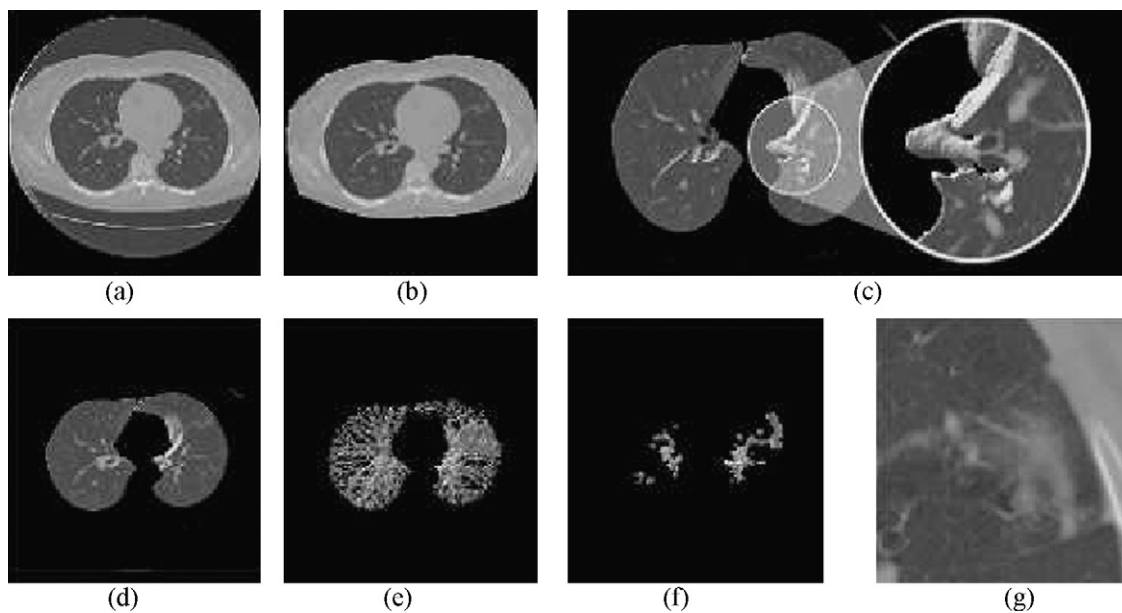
Case study – unsuccessful detection. (a) 2D visualization of the original CT exam. (b) Eliminates of all artifacts external to the patient's body. (c) Removal of thorax just remaining the parenchyma and shows the incorrectly eliminated internal structures, making necessary the reconstruction of the lungs perimeter. (d) Shows the reconstructed parenchyma. (e) 3D Visualization of the remaining structures after threshold application. (f) Shows that the elimination of the blood vessels resulted in the elimination of part of the nodule, damaging the detection. (g) Shows the original CT and as the contour nodule is very fuzzy.
